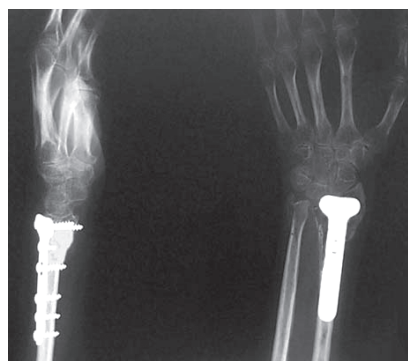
Radiographs on PA and lateral planes, showing bone union after 12 weeks of surgical treatment of pseudoarthrosis of distal radius fracture in patient number 1.
